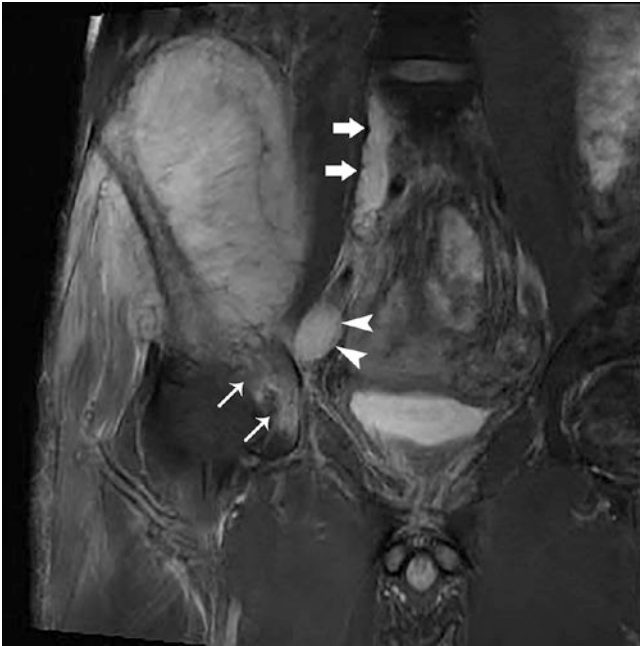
A 36-year-old man with osteosarcoma of the right ilium. Coronal T2-weighted fat-saturated image of the pelvis demonstrates the large primary tumor with invasion into the right hip joint (skinny arrows), a right external iliac lymph node metastasis (arrowheads), and tumor thrombus in the right common iliac vein (fat arrows)
